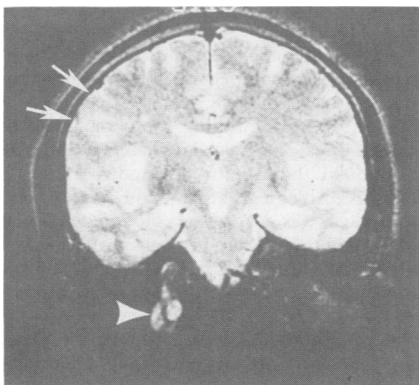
Figure Spin Echo T₂ weighted MRI (TR 2000 ms, TE = 70 ms) showing dissection of right internal carotid artery (arrowhead) and right parietal infarction (arrows).
